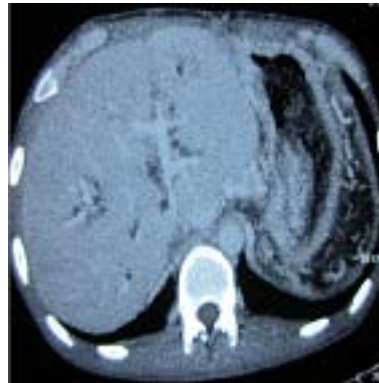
The enhance CT detect the blood flow in the intra-hepatic portal vein.
